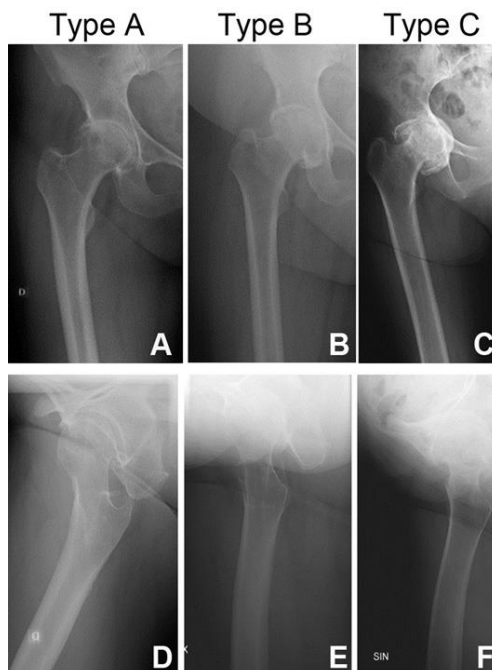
Dorr classifications. Representative radiographs of Dorr type A, B and C proximal femurs in A/P (A-C) and lateral view (D-F).
